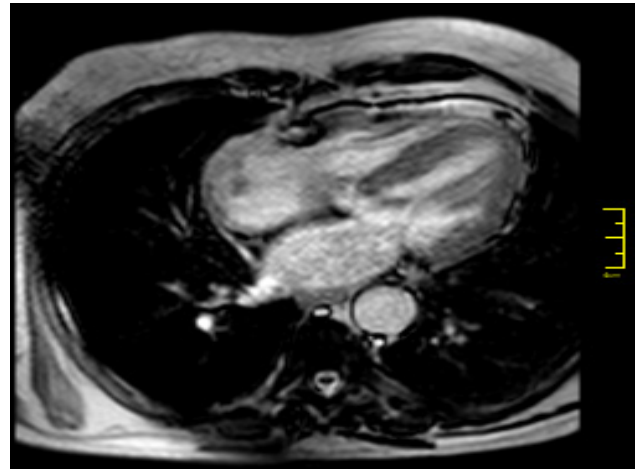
Magnetic resonance imaging (MRI) of the heart.
